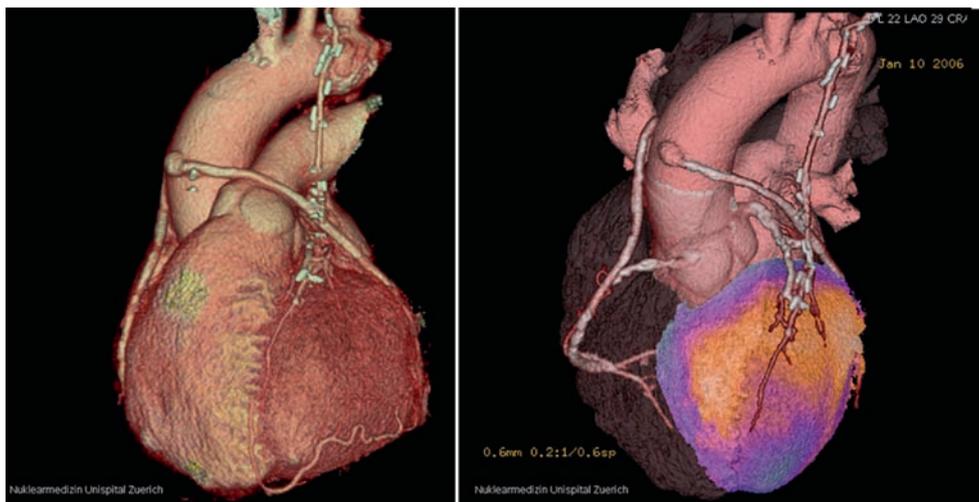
In situations of complex coronary CAD and after bypass surgery hybrid cardiac imaging provides added value. CT coronary angiography may allow visualization of patent bypass grafts but the evaluation of the anastomoses remains difficult. A conclusion about
